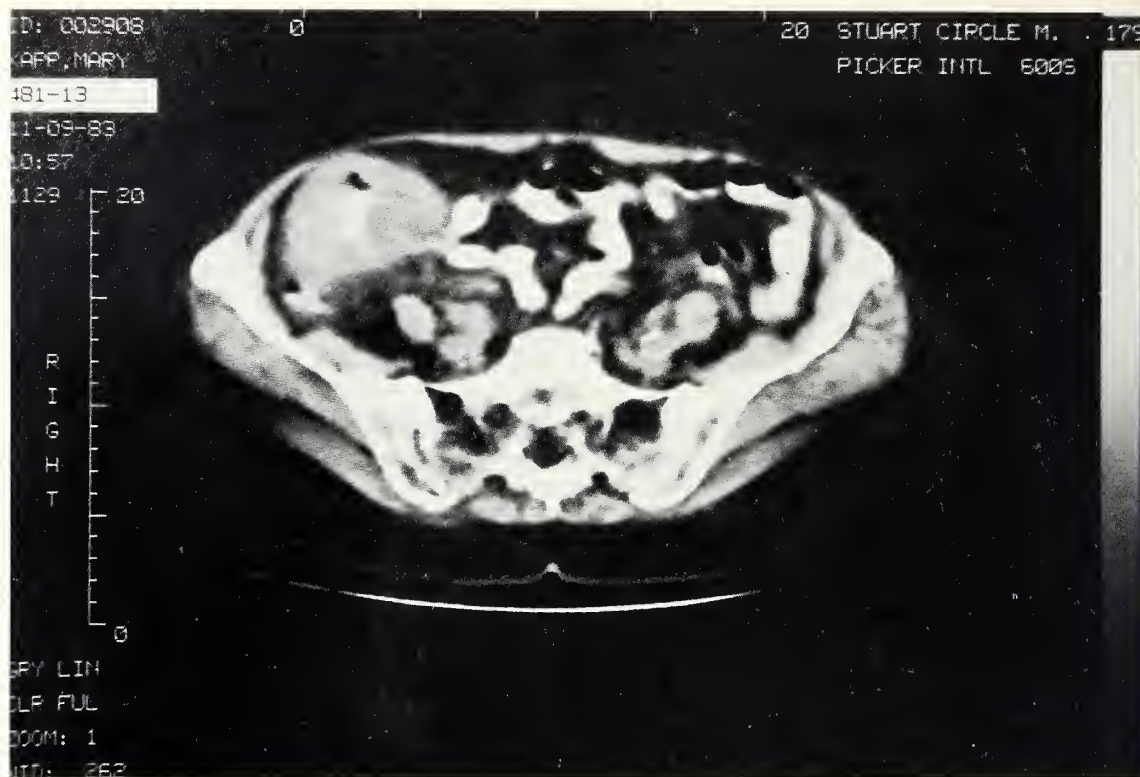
CT scan revealed 7.5-cm soft tissue mass.
